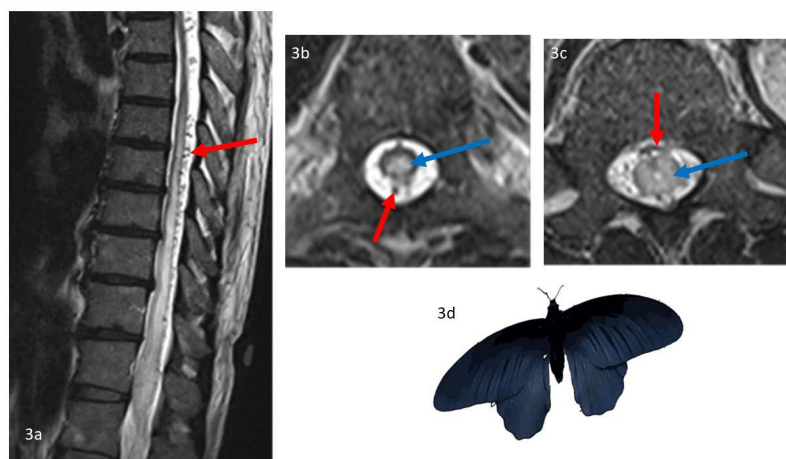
Black butterfly sign. 22 year old male with cord edema secondary to thoracic spinal dural arteriovenous fistula (DAVF). (3a) Sagittal T2-weighted spinal MRI showing a swollen lower thoracic spinal cord with central hyperintensity surrounded by tortuous, serpentine and dilated perimedullary venous plexus with flow voids (red arrow). Axial T2-weighted images at T8 (3b) and T12 (3c) levels show T2-weighted hyperintensity of the cord (blue arrows) surrounded by engorged perimedullary venous plexus with flow voids (red arrows). Siemens Aera, 1.5 Tesla, Slice width 3.0 mm, TR 4000, TE 86, FA 150. (3d) An image of a black butterfly.
